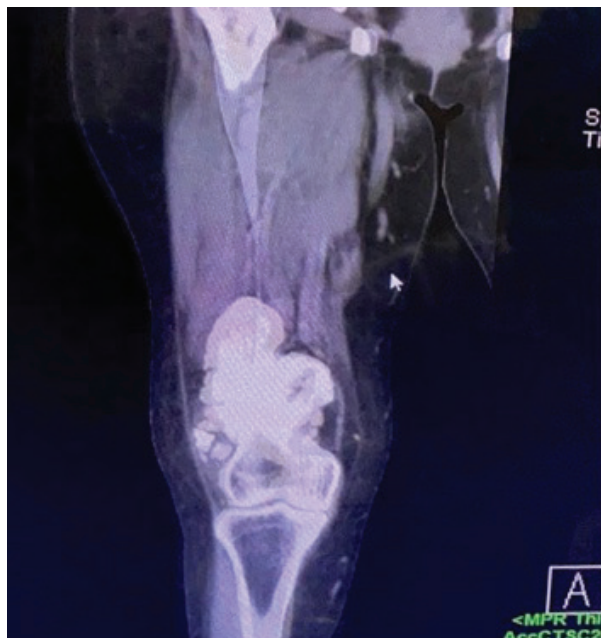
Pre Op X-ray Distal end Femur
